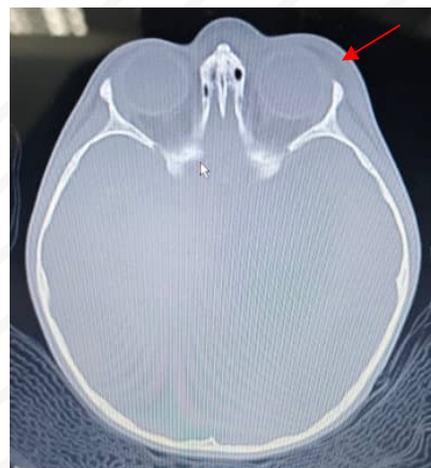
CT Brain showed increase in swelling of soft tissue over the left orbital region (red arrow)
